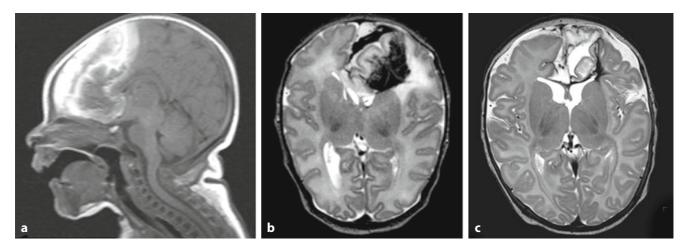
Full-term infant, easy vaginal delivery, admitted with neonatal seizures. MRI on day 7 (\mathbf{a} and \mathbf{b}) and at 3 months (\mathbf{c}), showing a supratentorial subdural hemorrhage and a large frontal intraparenchymal hemorrhage, with a shift of the midline. A repeat scan at 3 months, shows resolution of the hemorrhage and associated loss of brain tissue
